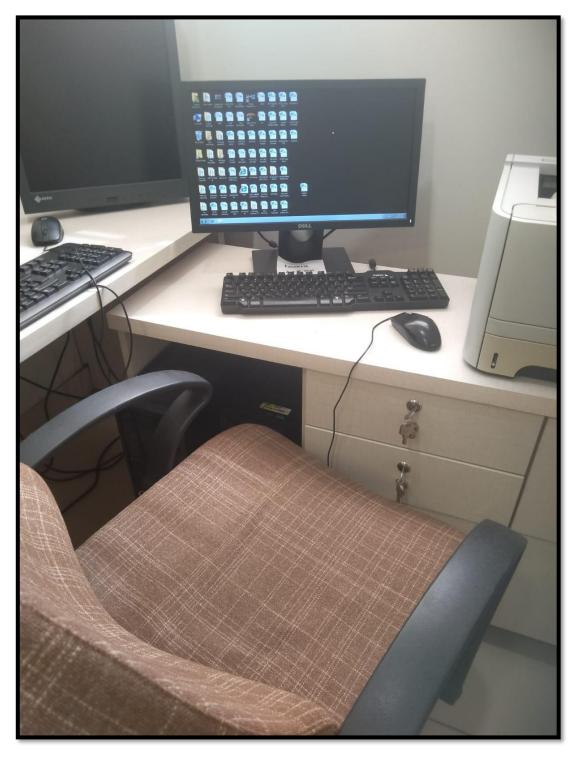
Ultrasound Reporting Room
